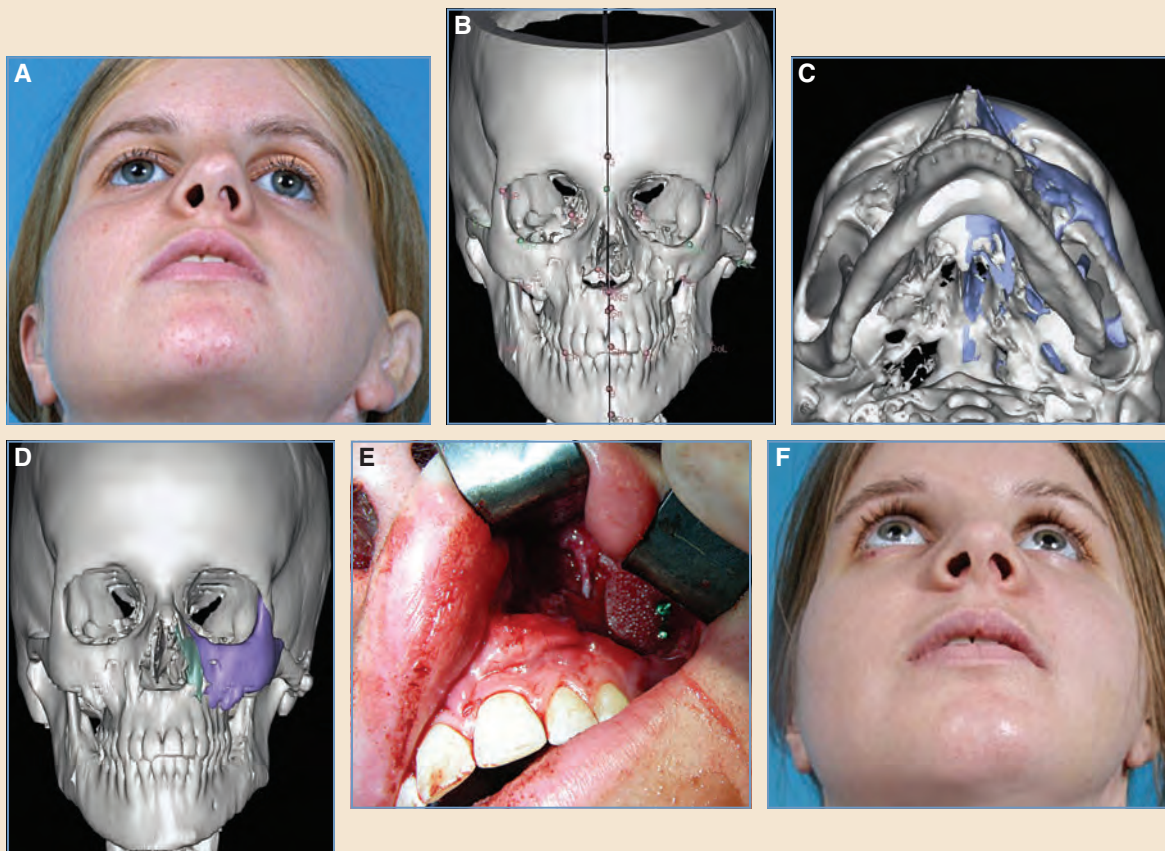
This patient had left CFM after a LeFort I osteotomy and a bilateral sagittal splitting osteotomy. A, A worm's-eye view showed residual midface asymmetry. B, A three-dimensional CT scan revealed residual zygomatic deficiency. C and D, Three-dimensional CT planning for correction of bony asymmetry with an alloplastic implant. E, Intraoperative placement of a porous polyethylene implant. F, The postoperative result.
